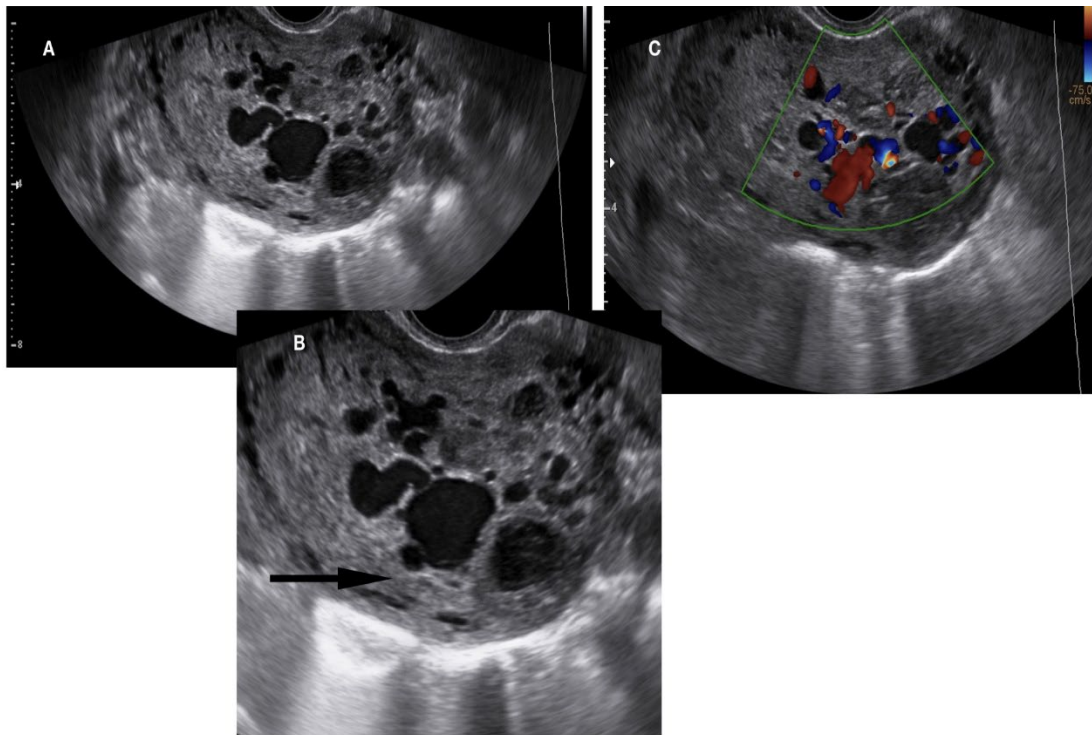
A complete abdominal and pelvic computed tomography (CT) scan showed an image of a dilated vein on the left side of uterus body, ultrasonography view.
